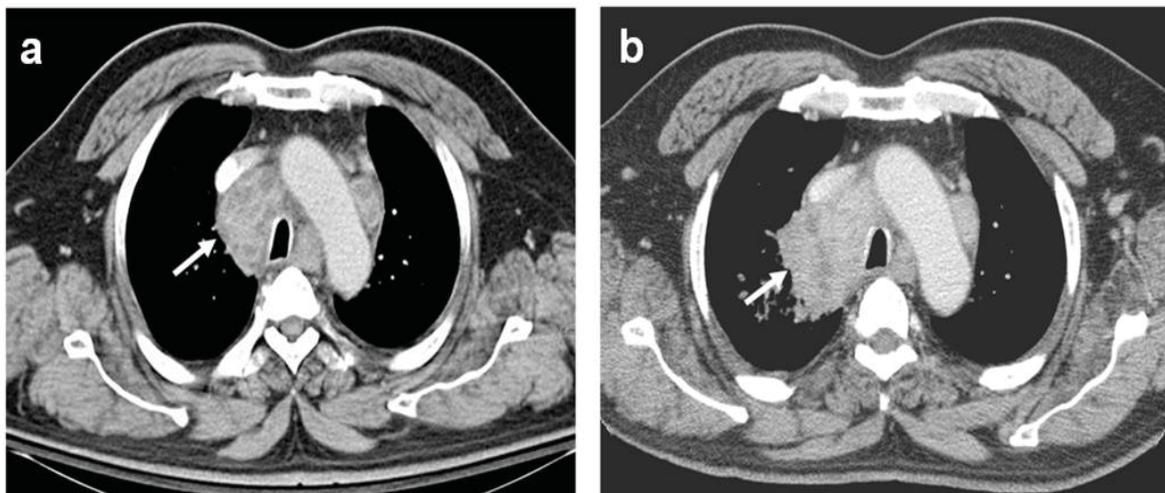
Serial computed tomography shows progressive change (see arrows) of lymph nodes in the mediastinum: (a) multiple enlarged lymph nodes in the mediastinum upon patient’s admission, and (b) progressive necrotic change of lymph nodes with invasion of the upper lobe of the right lung on day 25.
